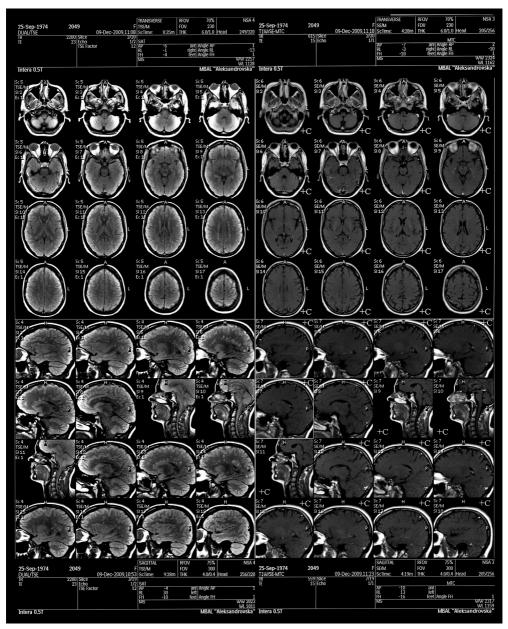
MRI in a patient with RRMS after Glatiramer acetate treatment
